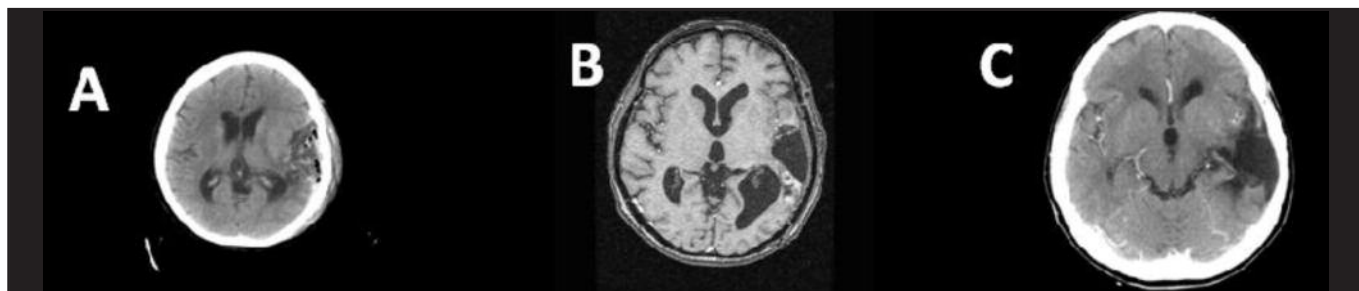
A: CT brain immediately after the surgery shows residual tumours. B and C: Follow-up MRI (1 year after therapy) and CT brain (2 years after therapy) show areas of encephalomalacia and no tumour recurrence.
